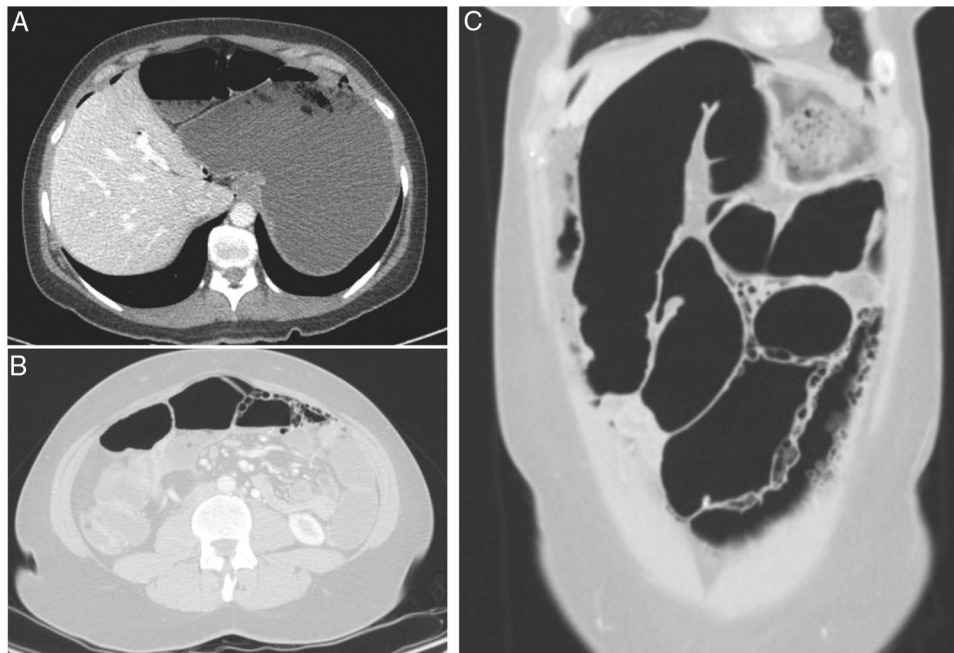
CT enterography (A, axial image; B and C, axial and coronal images, lung window) demonstrates free extra-peritoneal gas (arrows) and multiple air-filled cysts in the small bowel walls. There were no other abnormalities in the small bowel or in the colon.
